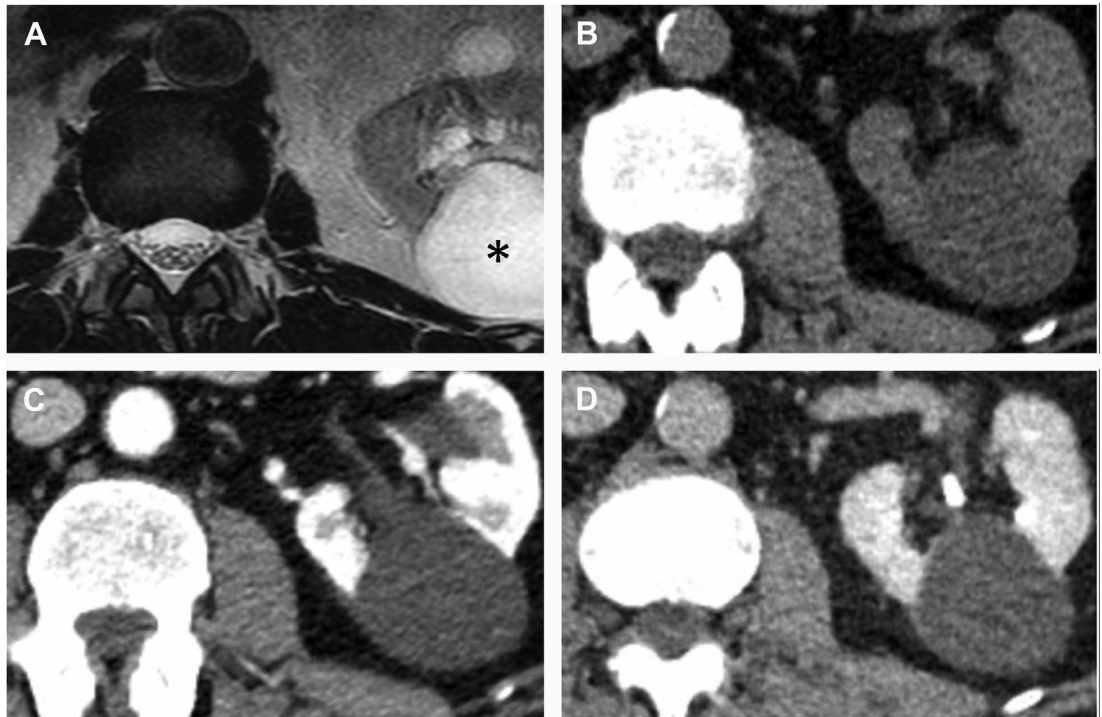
A 55-year-old man with an incompletely imaged 4.5-cm homogeneous left renal mass (*asterisk*) that is markedly hyperintense at T2-weighted imaging (similar to cerebrospinal fluid) from a noncontrast spinal MR imaging that was obtained in 2018 (A), before the latest updates to the Bosniak classification system. A follow-up renal CT scan demonstrated a mildly hyperdense lesion (25 HU) on unenhanced phase (B), and no enhancement on corticomedullary phase (C) or nephrographic phase (D). This was characterized as a Bosniak type II renal cystic mass. According to the Bosniak classification system version 2019, the noncontrast MR imaging findings are sufficient to classify this as a Bosniak type II renal cystic mass, and no further characterization is needed.
